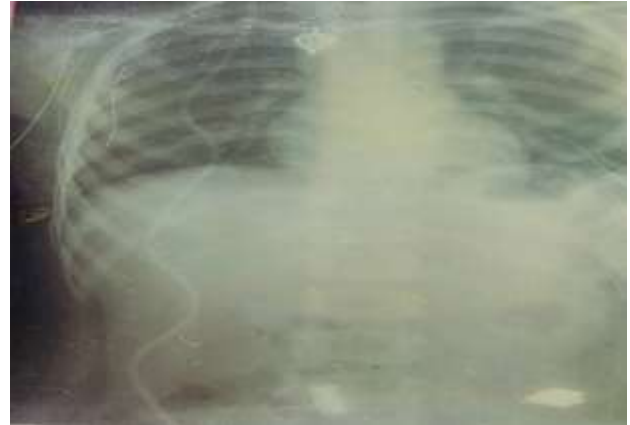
Plain chest and abdominal radiograph showing peritoneal end of VP shunt entering pelvis.
